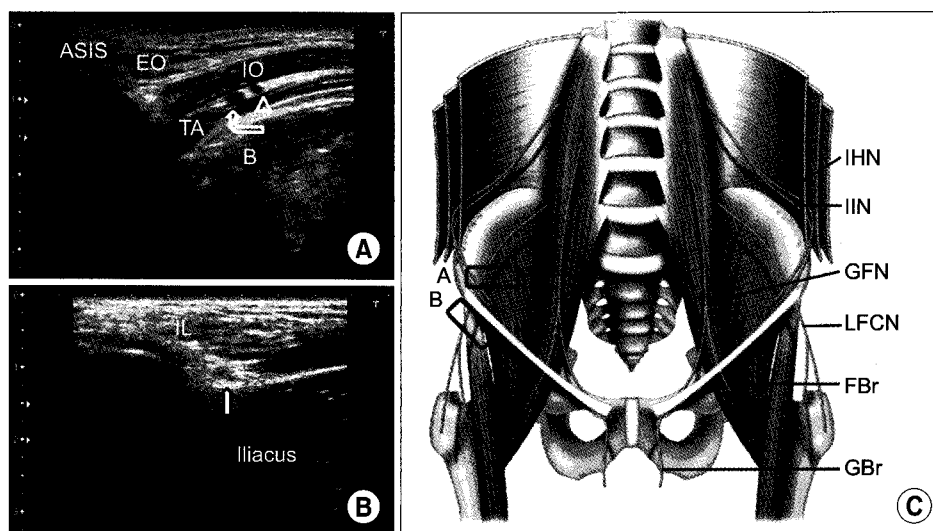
Ultrasound-guided nerve blocks for post-hernia repair pain. (A) Transverse 10 MHz ultrasound image obtained medial to the anterior superior iliac spine (ASIS). Ilioinguinal (curved arrow) and iliohypogastric nerve (arrow head) lie in the fascial plane between internal oblique (IO) and transverse abdominus (TA) muscles. EO: external oblique muscle, B: bowel. (B) Oblique 12 MHz ultrasound image obtained caudal to the anterior superior iliac spine. Lateral femoral cutaneous nerve (LFCN) lies medial to ASIS just below the inguinal ligament (IL). (C) Course of the ilioinguinal (IIN), iliohypogastric (IHN), genitofemoral (GFN) and lateral femoral cutaneous nerves (LFCN) through the muscular layers of the abdomen. FBr: femoral branch of the GFN, GBr: genital branch of the GFN.
